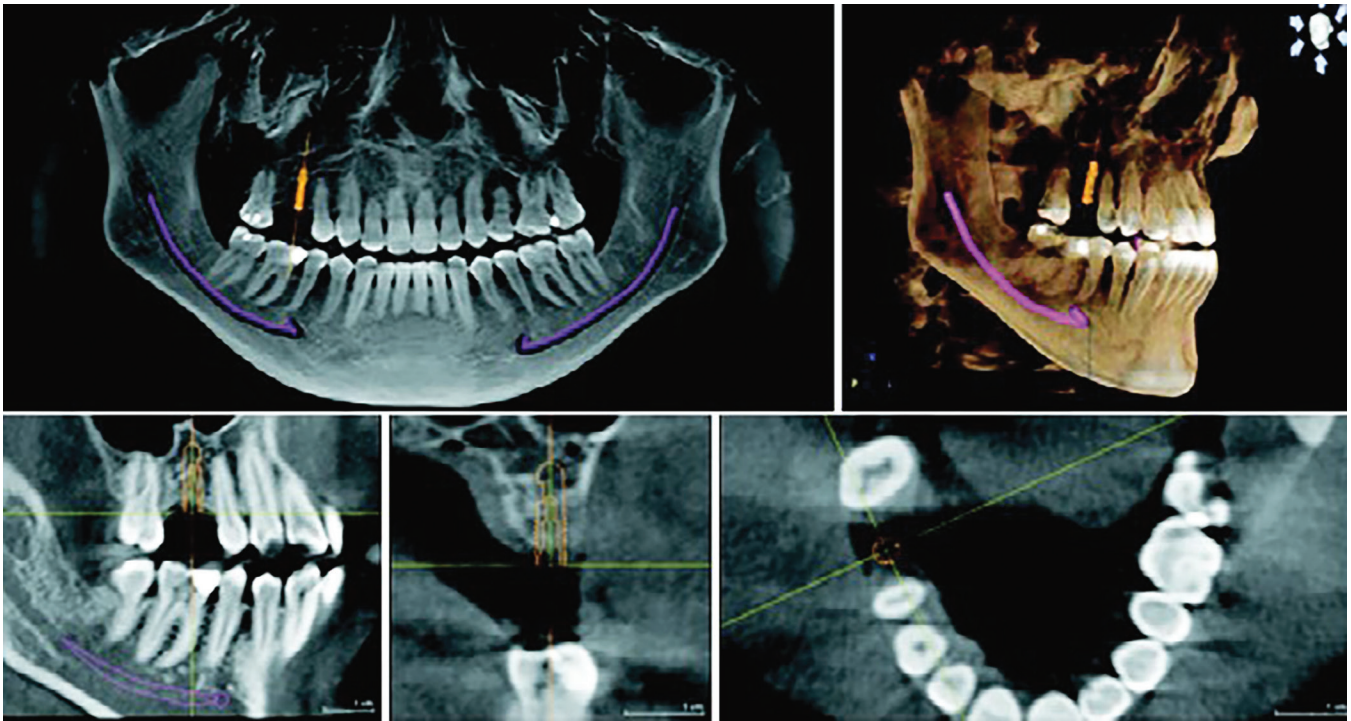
The CBCT-guided implant
